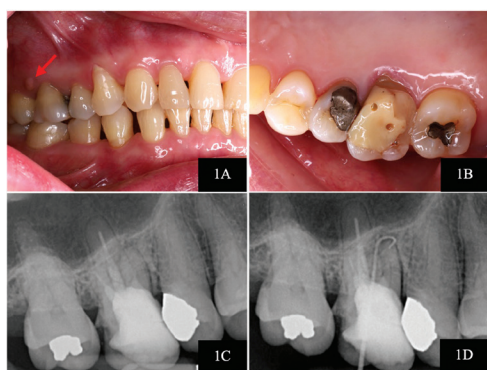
Preoperative assessment. (1A) A red arrow pointing sinus tract opening at the buccal gingiva; (1B) Intraoral photograph showing the fracture of the distopalatal part of maxillary right first molar; (1C) Preoperative periapical radiograph; (1D) Preoperative periapical radiograph with gutta-percha tracing.
